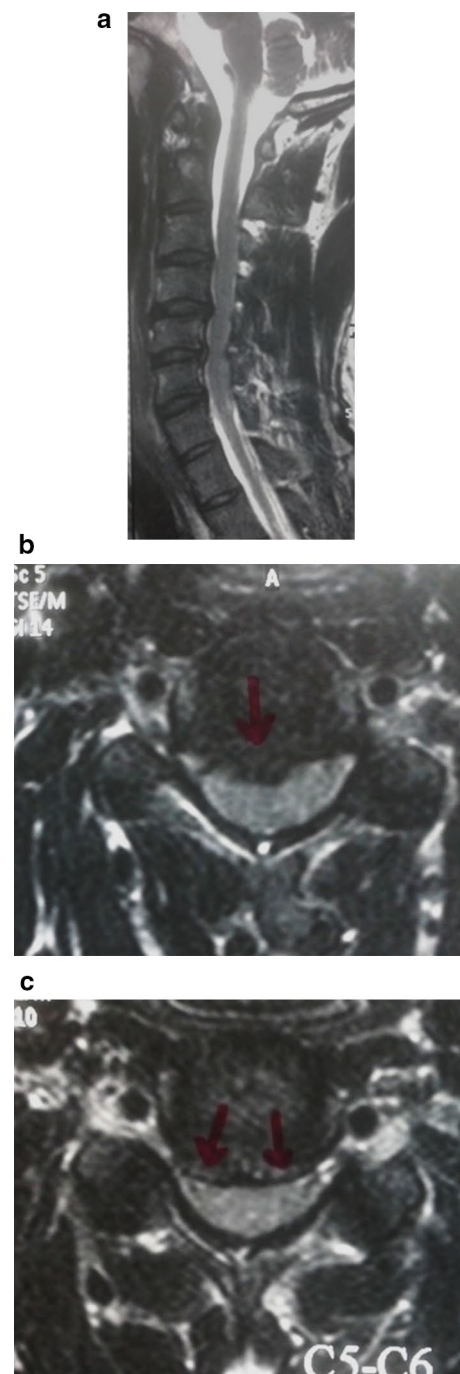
a Sagittal MRI showing compression at C4–C5 and C5–C6. b Axial MRI showing compression at C4–C5. c Axial MRI showing compression at C5–C6
